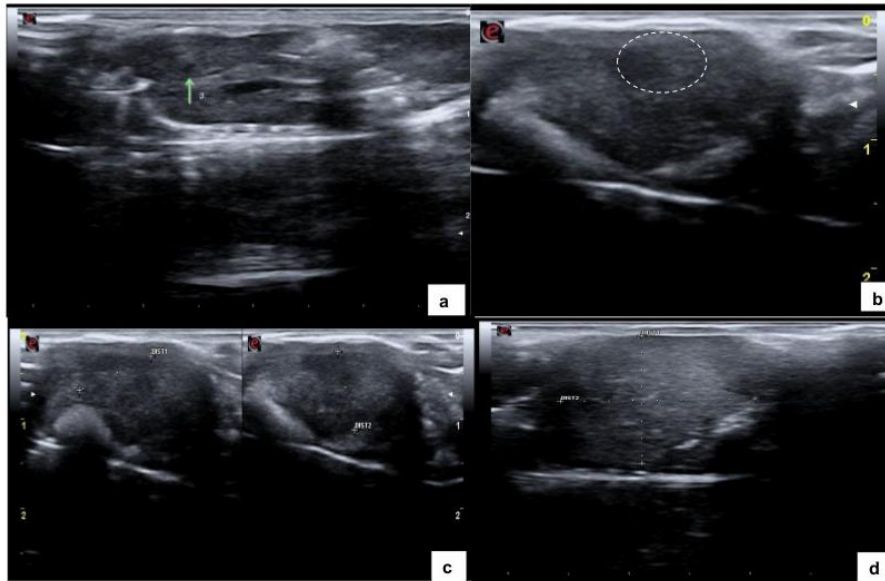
(A) Ultrasound image of liver parenchyma showing a small, homogeneous hypoechoic nodule within the liver parenchyma measuring 1.2 mm in length along the longitudinal axis (green arrow). (B) Homogeneously hypoechoic nodule (dashed oval), distinct borders measuring 4.8mm. (C) Heterogeneously hypoechoic nodule measuring 12 mm × 8.2 mm (green arrow). (D) Heterogeneously hyperechoic nodule occupying a large portion of the liver parenchyma (dashed oval), measuring 17.1 mm in length along the longitudinal axis (diameter 2).
